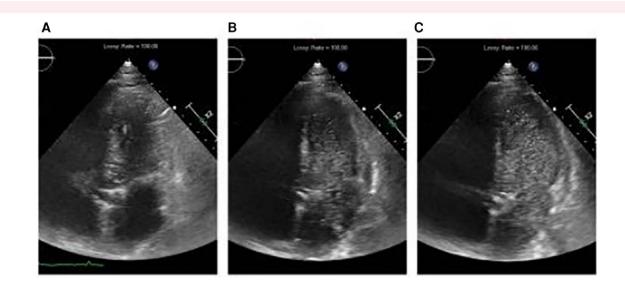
Three sequential images from the apical four-chamber views. (A) Before the injection of agitated saline through the nasogastric tube. (B) Immediately after the injection, bubbles appear in the left atrium and ventricle. It can be clearly seen that the bubbles are entering the left atrium from the posterior aspect of the roof. (C) The bubbles fill the left atrium and ventricle.
